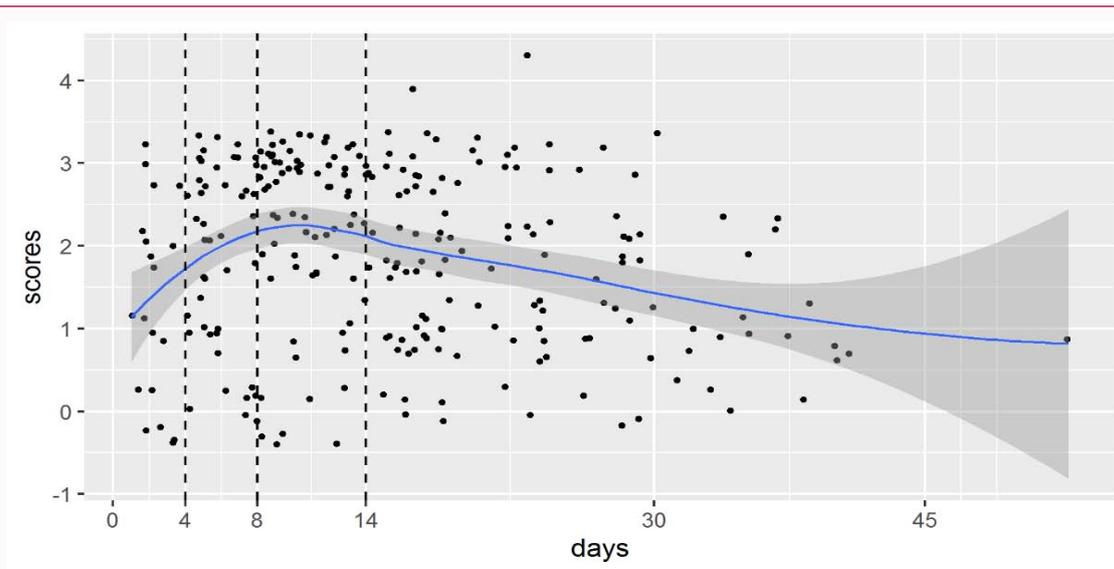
The overall trend of scores showing degrees of lesions involvement in four phases of chest CT images in clinical.
